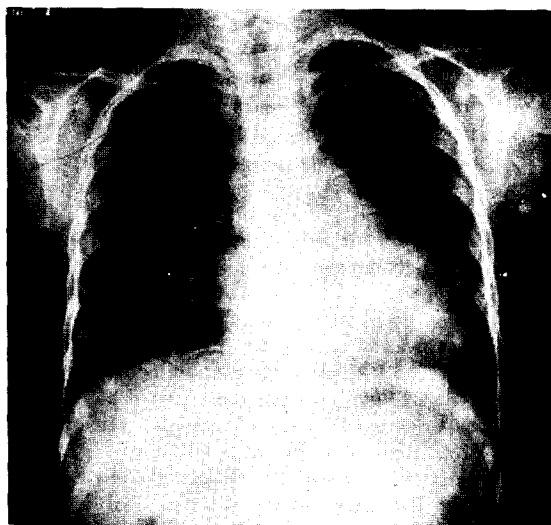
The postoperative chest X-ray findings, showing decreased heart size and pulmonary vascularity.
